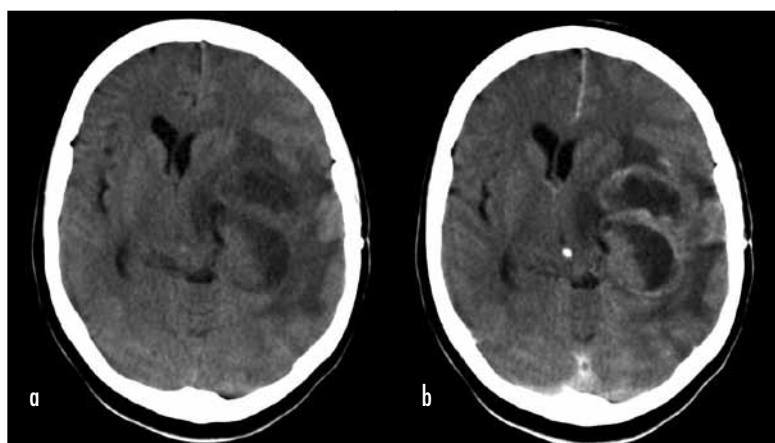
a. A pre-contrast computed tomography scan showing left-sided mixed attenuation lesions causing mass effect and ventricular effacement. b. The same patient following intravenous contrast, demonstrating the ring enhancement pattern of a primary brain tumour.
